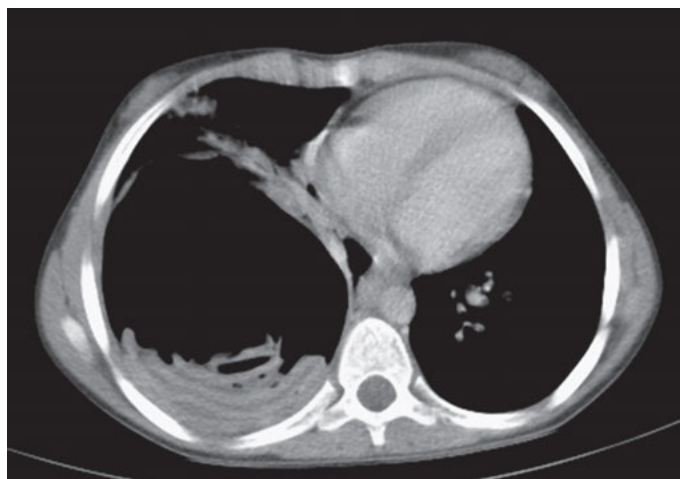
A computed tomography scan showing a ruptured echinococcal cyst containing detached membranes inside the cystic cavity (the as whirl (or spin) sign (CE3a stage).
